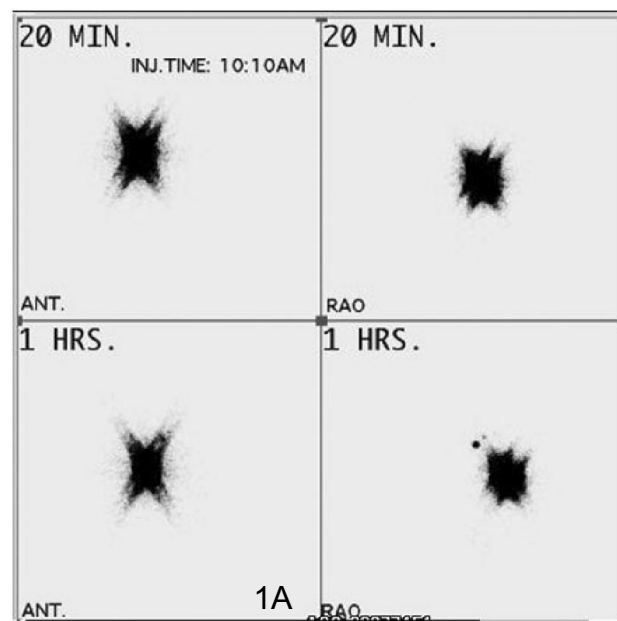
(A): Sentinel lymph node scintigraphy image showing uptake of radiotracer in the left sentinel node at 01 hour.
